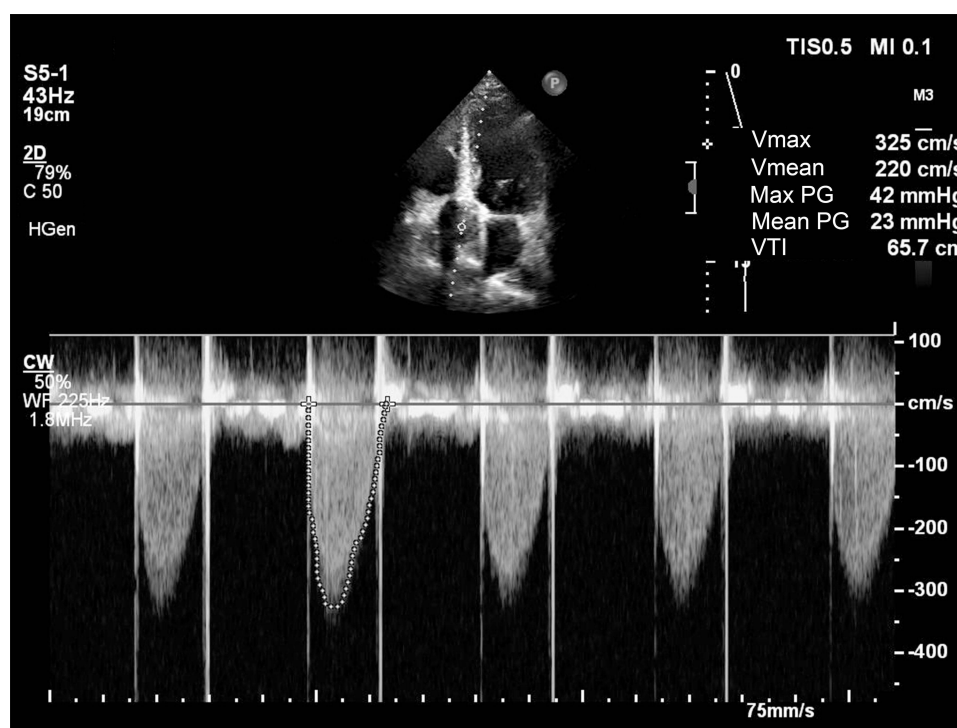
Transthoracic echocardiogram revealed a slight increase in the forward flow rate of the mechanical valve after aortic mechanical valve replacement.
